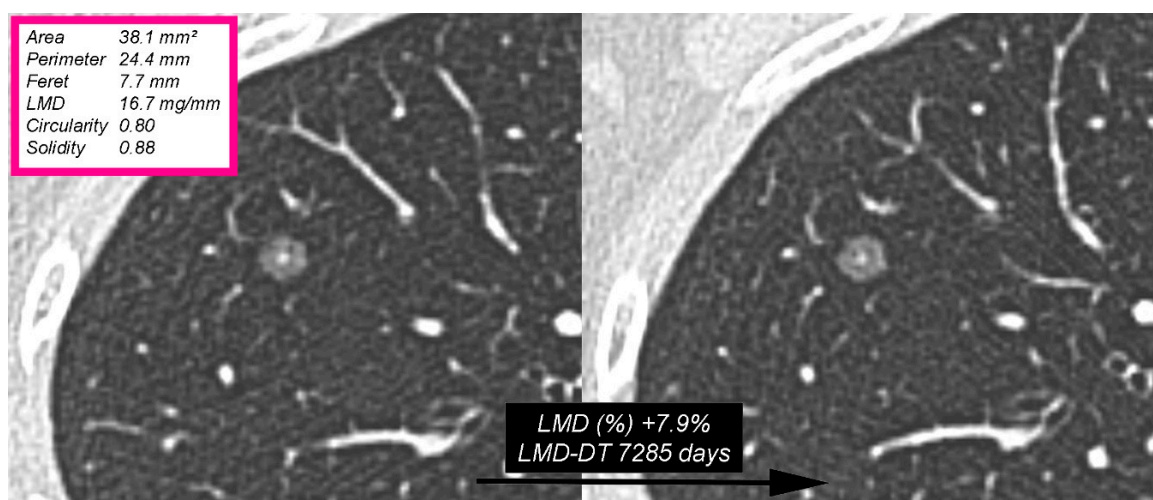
Nongrowing part-solid nodule (PSN) in the right upper lobe in a 43-year-old woman (nonsmoker and without an oncologic history). The PSN exhibits a rounded shape. The interval between the baseline (left) and last follow-up CT scan (right) was 789 days. The computerized analysis showed a relative linear mass density (LMD) variation of +7.9% in the nodule (less than the cut-off of 11.3%) with a LMD-doubling time (LMD-DT) of 7285 days. The purple box (top left) shows the main quantitative features obtained from the baseline CT image.
